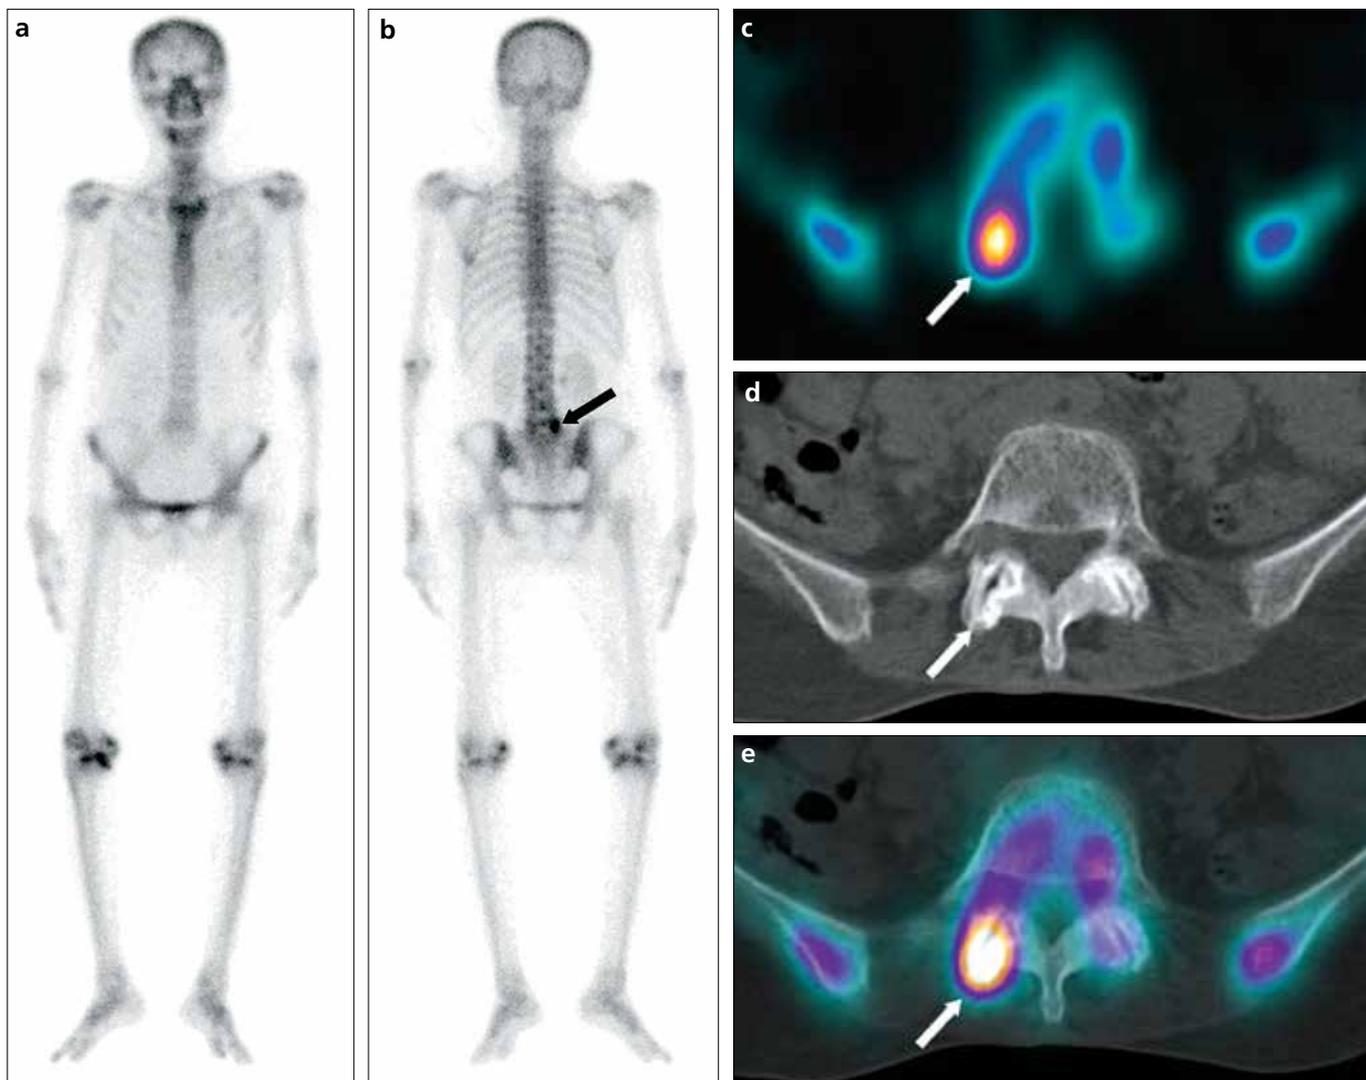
a–e. A 59-year-old female patient had therapy for carcinoma of the right breast. She presented with back pain. Bone scintigraphy was performed to rule out bone metastasis. Planar bone scintigraphy images (a, b) show focal uptake in the L5 vertebra (arrow; score 3). Axial SPECT (c) image shows uptake in the region of right facet joint of the L5-S1 vertebrae (arrow; score 5). Axial CT (d) and SPECT-CT (e) images show L5-S1 vertebrae right facet joint arthritis with increased tracer uptake (arrow; score 5). On these images, SPECT, CT and SPECT-CT characterized the planar scintigraphy indeterminate lesion as benign.
